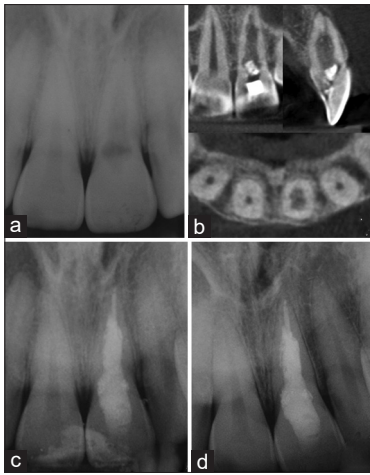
Internal inflammatory resorption of maxillary left central incisor. (a) Preoperative periapical radiography. (b) Cone beam computed tomography. (c) Endodontic treatment. (d) 24 months follow-up: Radiographic aspects
